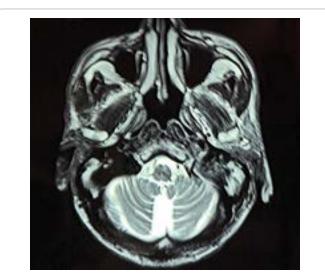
Axial Cerebral MRI of the Patient (T₂ weighted): Cerebellar Atrophy.
